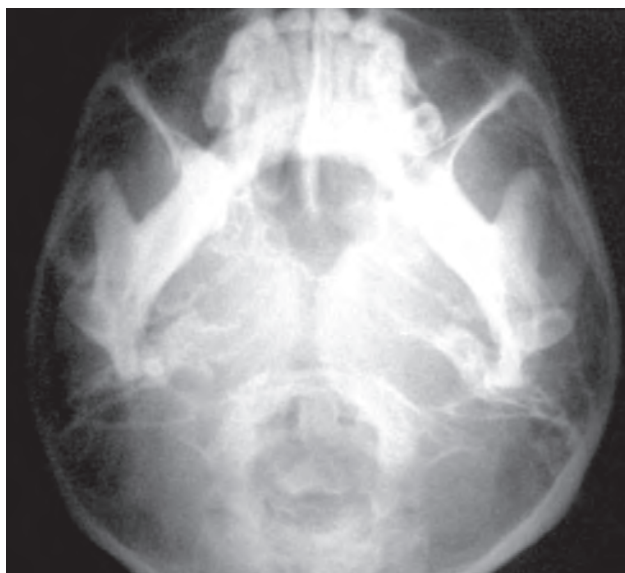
X-ray submento-vertical view
